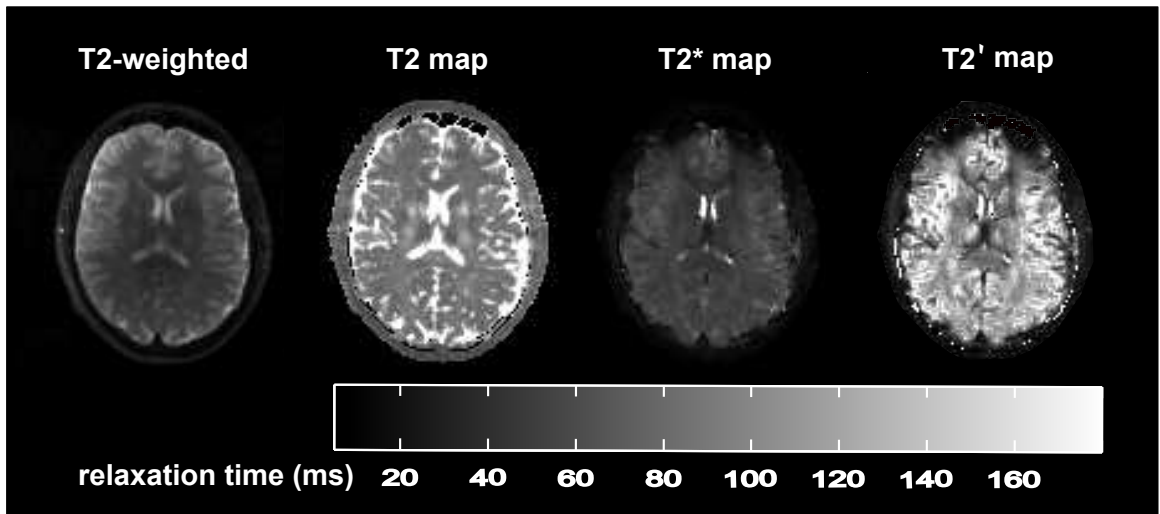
From left: filtered T2-weighted image ( $TE=100ms$ ), T2 map, T2\* map and T2' map. T2 and T2\* maps are calculated via a logarithmic fit to the spin echo and gradient echo data, respectively. The T2' is calculated from the T2 and T2\* maps via equation 1.20.
